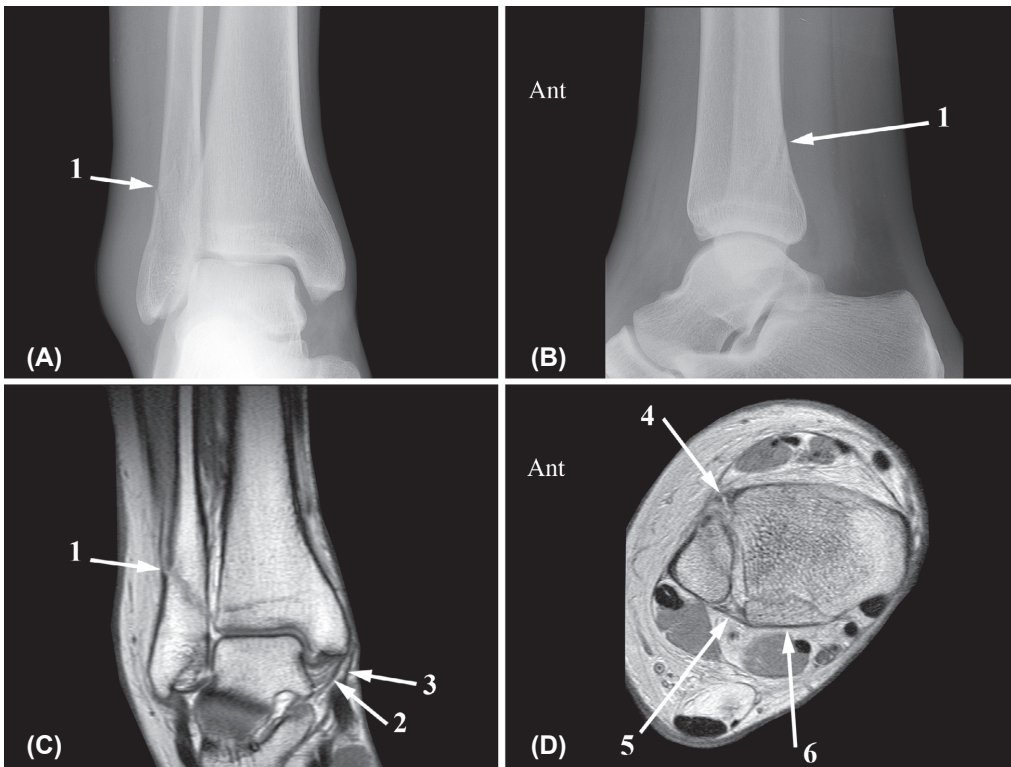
AP (A) and lateral (B) radiograph show a distal fibula fracture (1) at the level of the syndesmosis, running obliquely from antero-inferior to postero-superior, characteristic of a supination-external rotation trauma. Measurements are normal. This fracture is classified as: Weber type B, AO-Müller type B1.1 and Lauge-Hansen SE2. Coronal (C) and 45° oblique (D) proton-density-weighted MR image demonstrate the fibula fracture (1), and a normal deep (2) and superficial (3) deltoid ligament. The ATIFL is ruptured (4), whereas the intact PTIFL (5) is attached to an avulsion fracture of the posterolateral malleolus (6). This is therefore a Weber type B fracture with normal measurements but with anterior as well as posterior syndesmotic injury. According to Lauge-Hansen this is a SE3 fracture.
